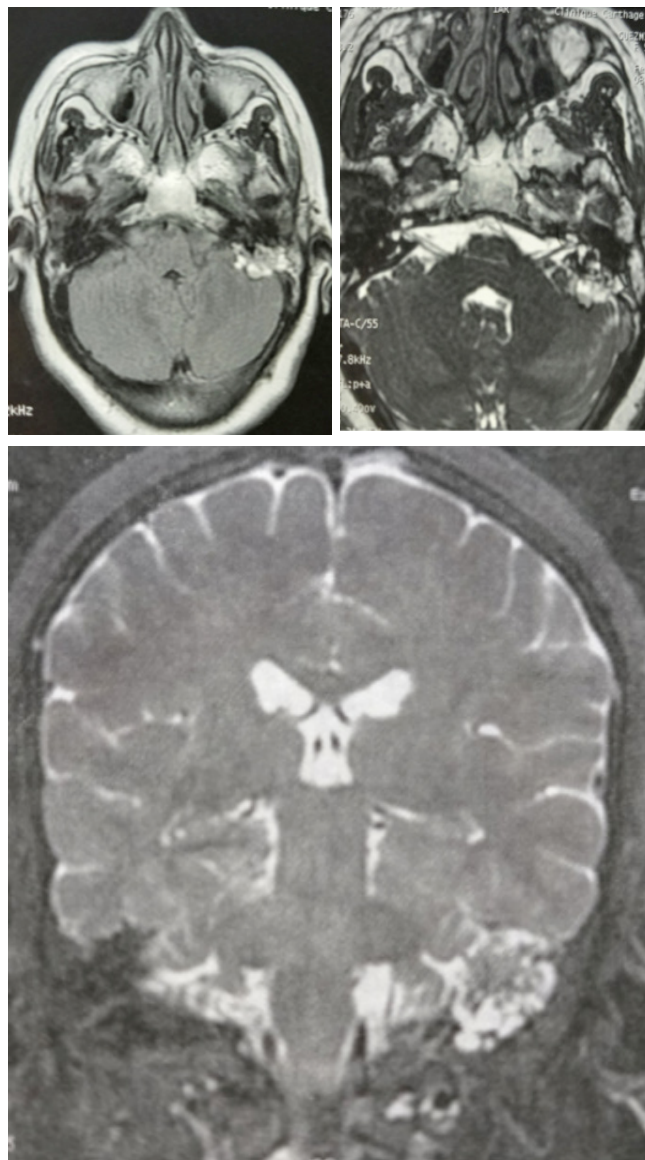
Axial MR images reveal a heterogeneous mass lesion involving the left endolymphatic sac and petrosal bone with extension into the left internal auditory canal. The mass is hypointense on T1 and hyperintense on T2 with heterogeneous enhancement.
